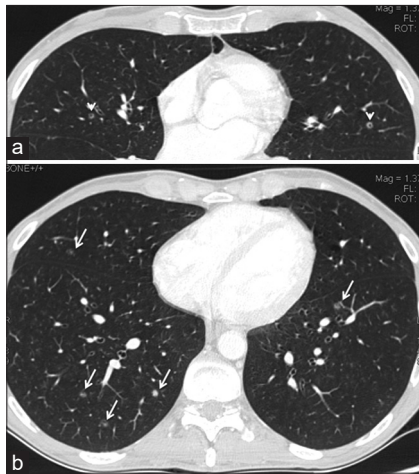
(a and b) New evidence of multiple small irregular micronodules (arrow) and thin-walled cyst (arrowhead) at chest-computed tomography (CT) underwent for high-grade testicular cancer follow-up
